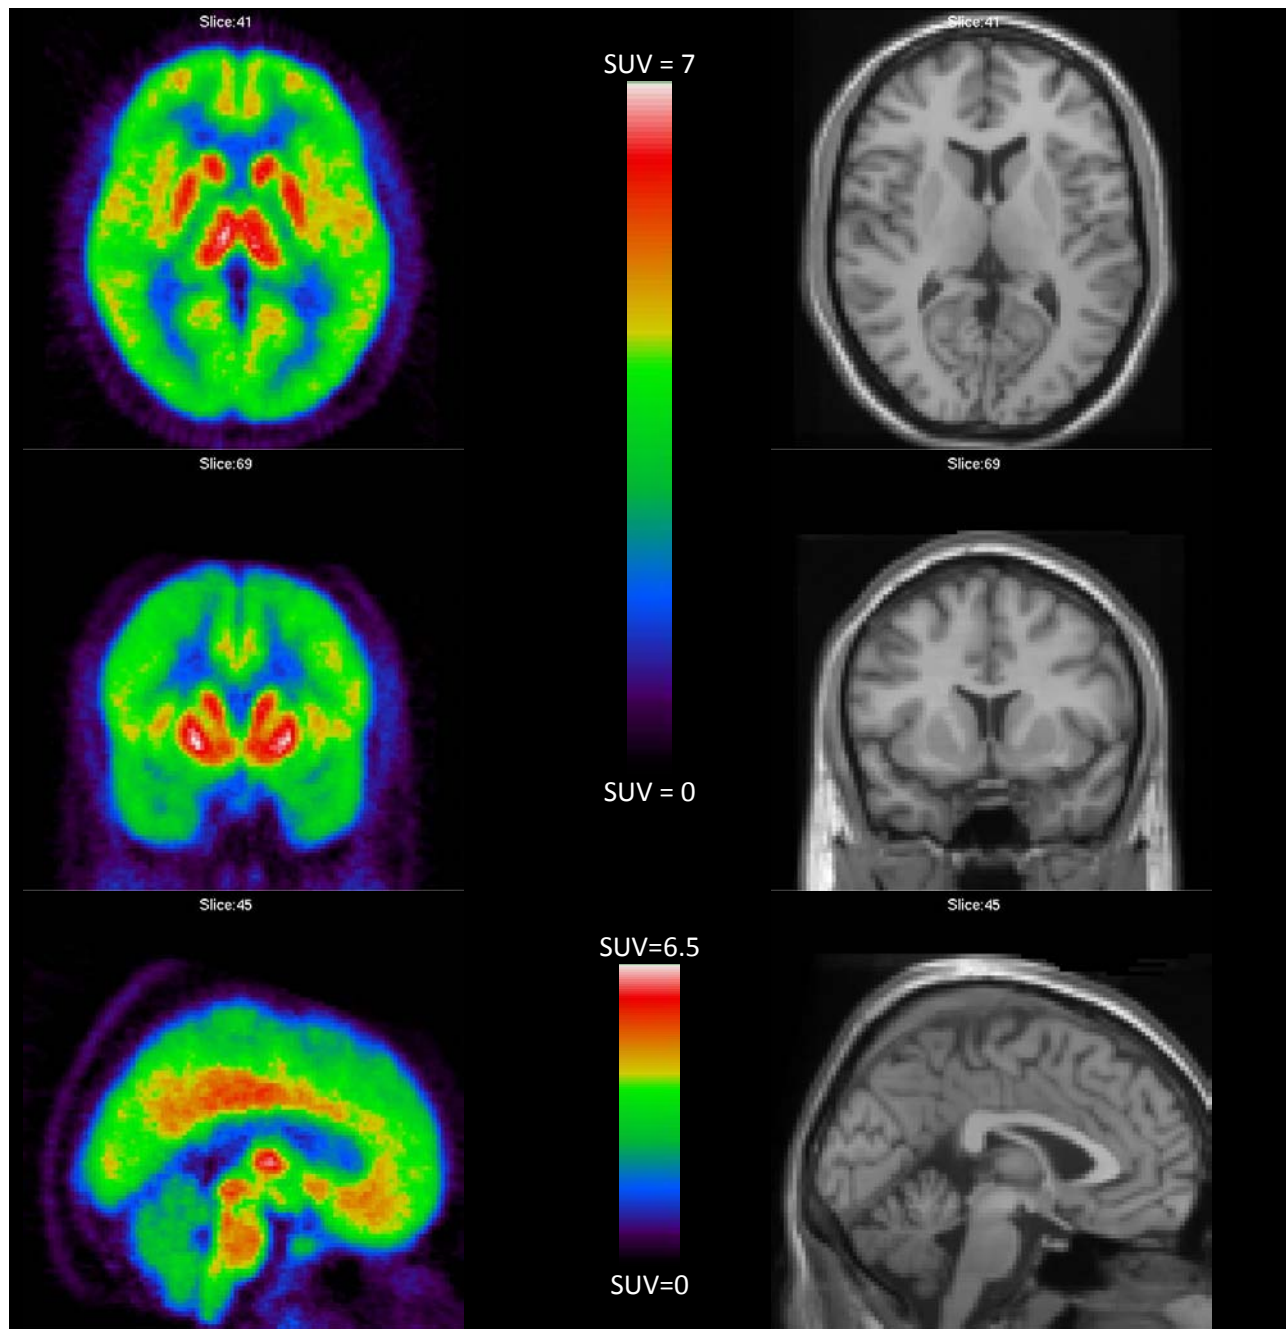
Left: average ( $n=14$ ) of brain uptake of  $[^{11}\text{C}]$ SL25.1188 in standard uptake values (SUV). The images were normalized to the MNI/ICBM space. Right: Single subject MRI in the same standard space for anatomical reference. In the top axial view 14 mm superior to anterior commissure (AC), middle: +6 mm anterior to the AC, bottom: interhemisphere plane.
